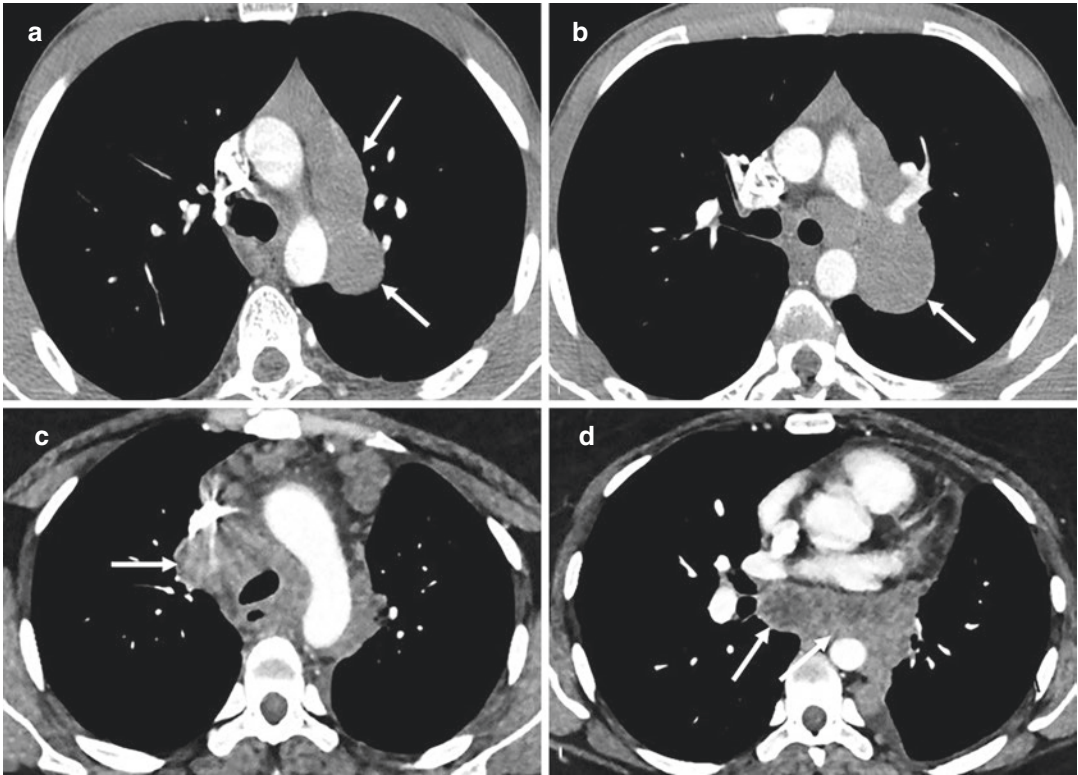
Different malignant conditions mimicking mediastinal lymph node tuberculosis. Axial contrast-enhanced CT images show (a and b) Hodgkin lymphoma with asymmetrical and homogeneous enlarged mediastinal
